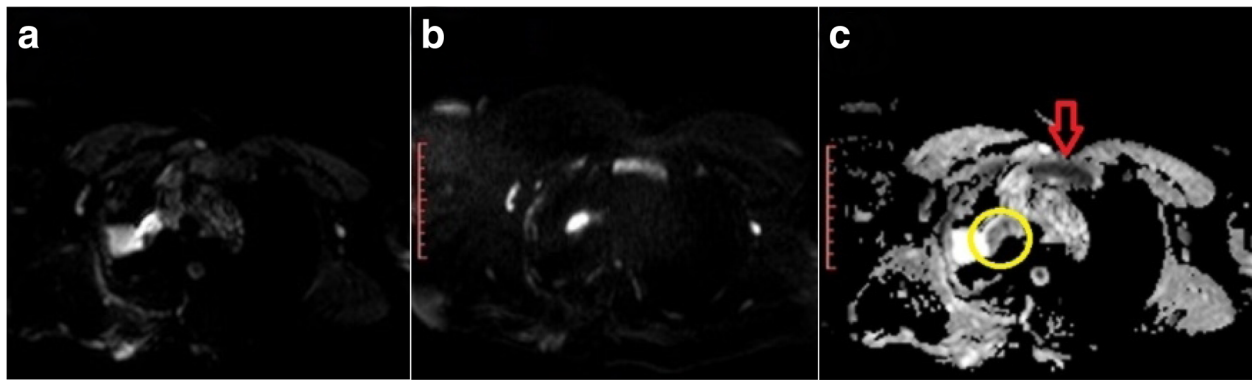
A 45-year-old female patient with right apical lung cancer, ipsilateral pleural effusion, and sternal metastasis. a Axial DWI. Medially located tumor and laterally located pleural effusion; both are showing restricted diffusion. b Axial DWI. Restricted diffusion of sternal metastasis. c ADC map. Low ADC in malignant tumor (yellow circle) and sternal metastasis (red arrow) but high in pleural effusion
